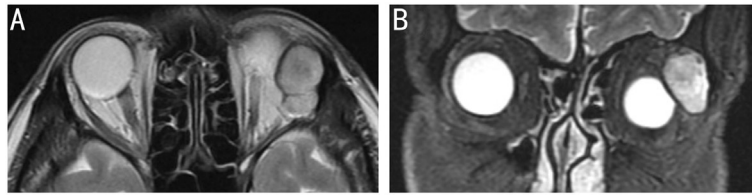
Imaging in a case with high intraocular pressure A: T2-weighted magnetic resonance imaging (MRI) of a coronal section showed a heterogeneous mass in the orbit of the left lacrimal gland region measuring 21.2×18.3×24.1 mm³; B: T2-weighted MRI of an axial section showed medial inferior deviation of the left eyeball.
